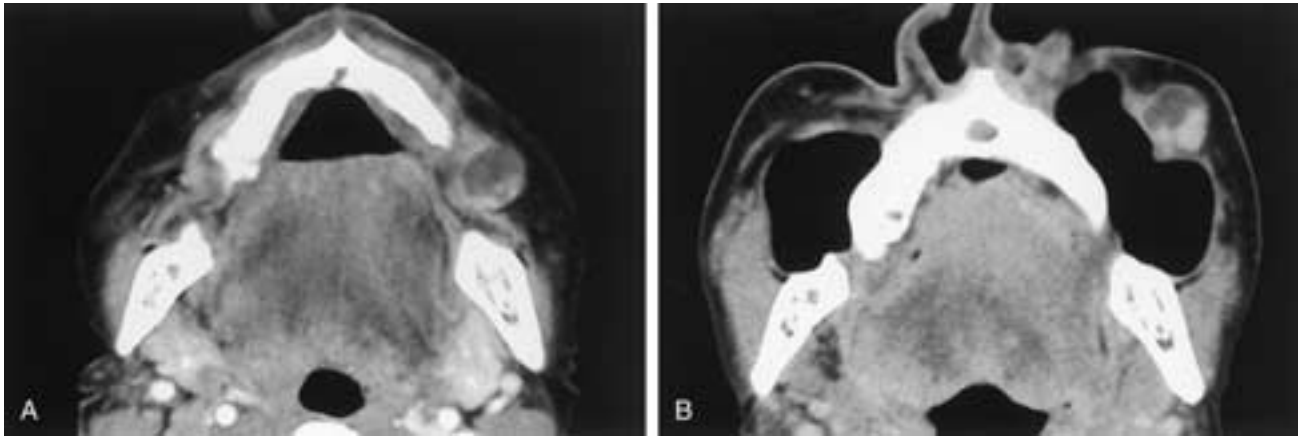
Value of the “puffed cheek” maneuver. A, Axial CT scan with the patient breathing normally. A mass has been identified, but it is difficult to determine if the mass arises from the gingival or buccal mucosa. B, Axial CT scan with puffed cheeks places air in the vestibule and confirms that the mass arises from the buccal mucosa. Pathologic examination revealed monomorphic adenoma.
